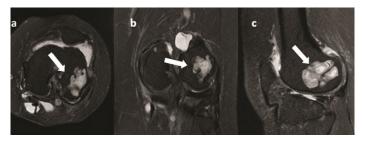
Axial (a), coronal (b) and sagittal (c) fat suppressed proton weighted MR images of a patient with mild osteoarthritis. An intraosseous ganglion cyst with lobulated contour and internal septa is observed in the lateral femoral condyle (arrows). A Baker cyst is also noted
